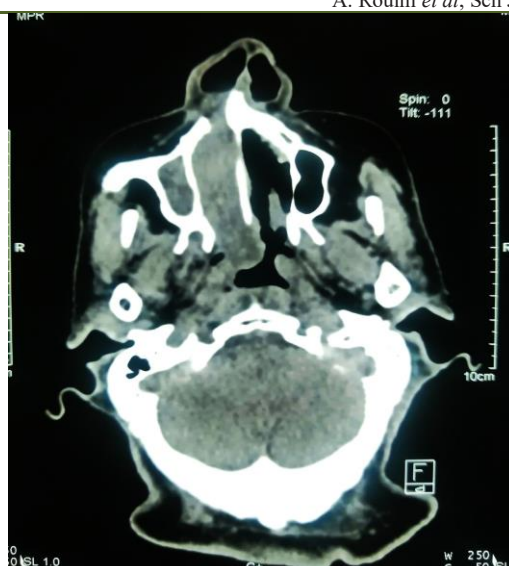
Preoperative axial section naso-sinus CT scan showing a right nasal polypoidal lesion arising from the olfactory slits
